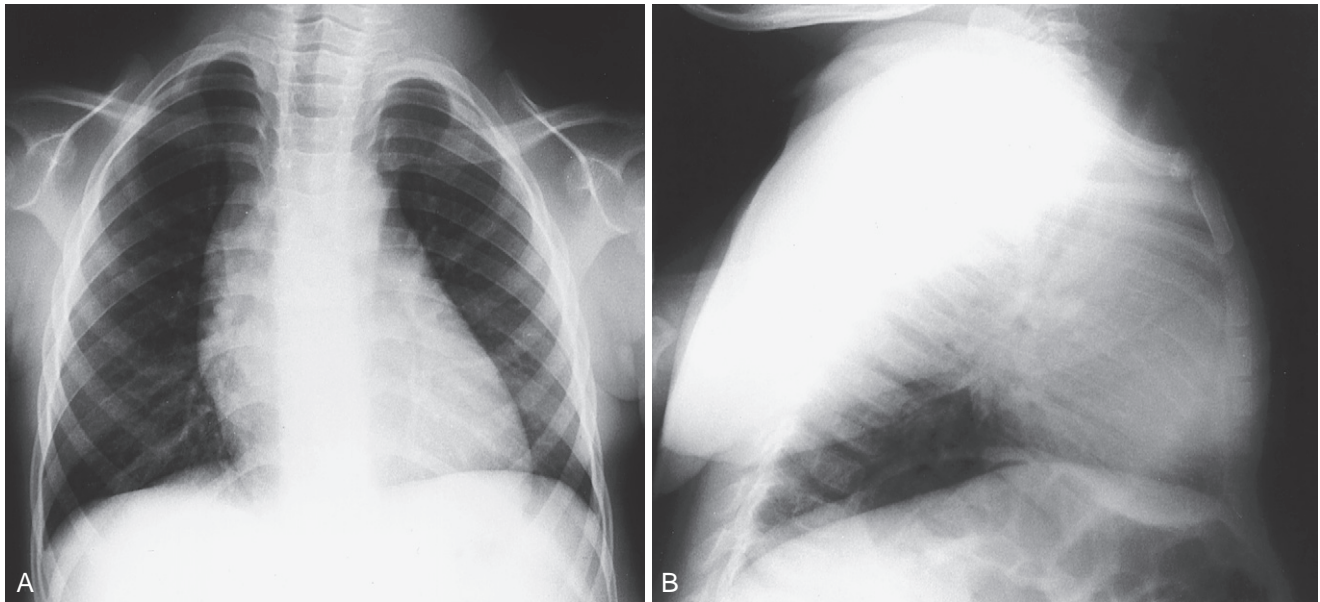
A 5-year-old boy presented with a superoanterior mediastinal mass noted to be separate from the pericardial silhouette on an anteroposterior chest film (A). Lateral chest radiograph (B) reveals sternomanubrial prominence and a mass anterior to the trachea. This mass turned out to be a teratoma.
